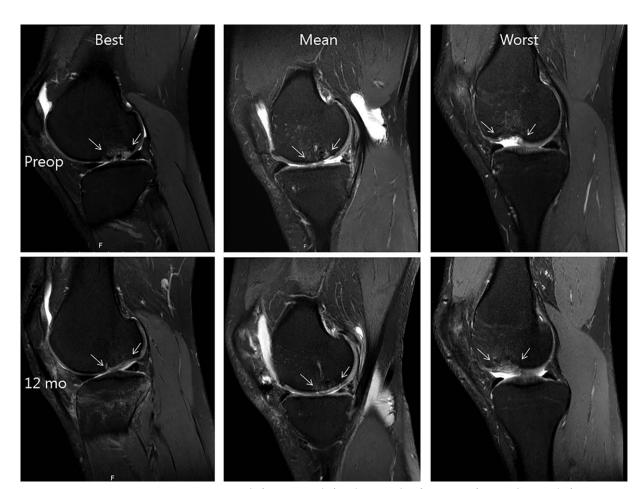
Magnetic Resonance Imaging preoperatively (preop, A and C) and 12 months after surgery (12 months, B and D). Representative images of the best, mean and worst results are obtained. Arrows indicate focal defect preoperatively and the repair tissue 12 months postoperatively. Abbreviations: mo, months.
